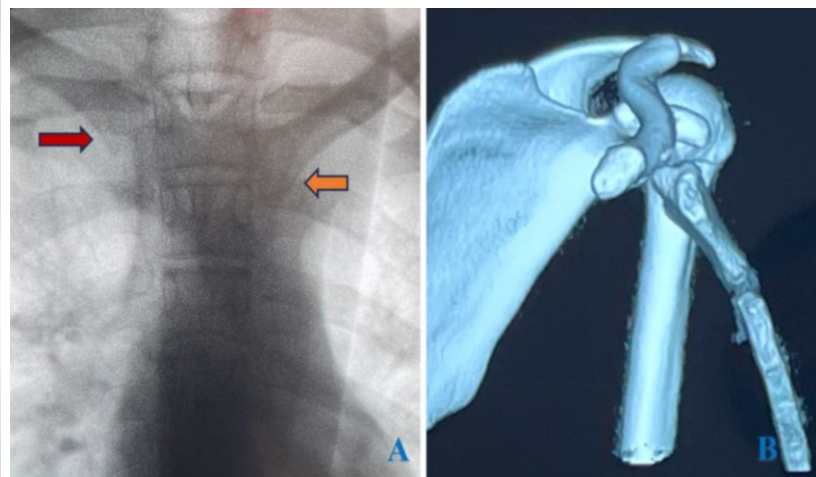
Imaging showing posterior dislocation of the left sternoclavicular joint. (a) Radiograph; (b) 3D computed tomography reconstruction.
